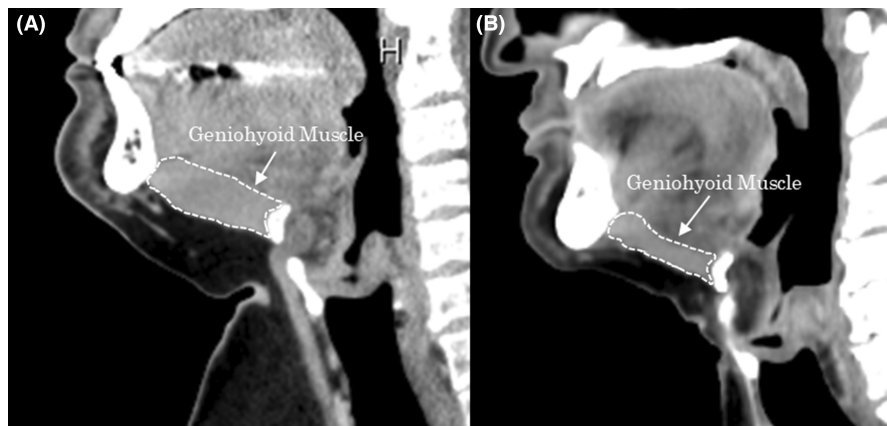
Representative computed tomography image used for the measurement of the geniohyoid muscle. (A) Non-sarcopenic case (GHMA 4.61 cm²). (B) Sarcopenic case (GHMA 2.50 cm²). GHMA: geniohyoid muscle sagittal cross-sectional area.
